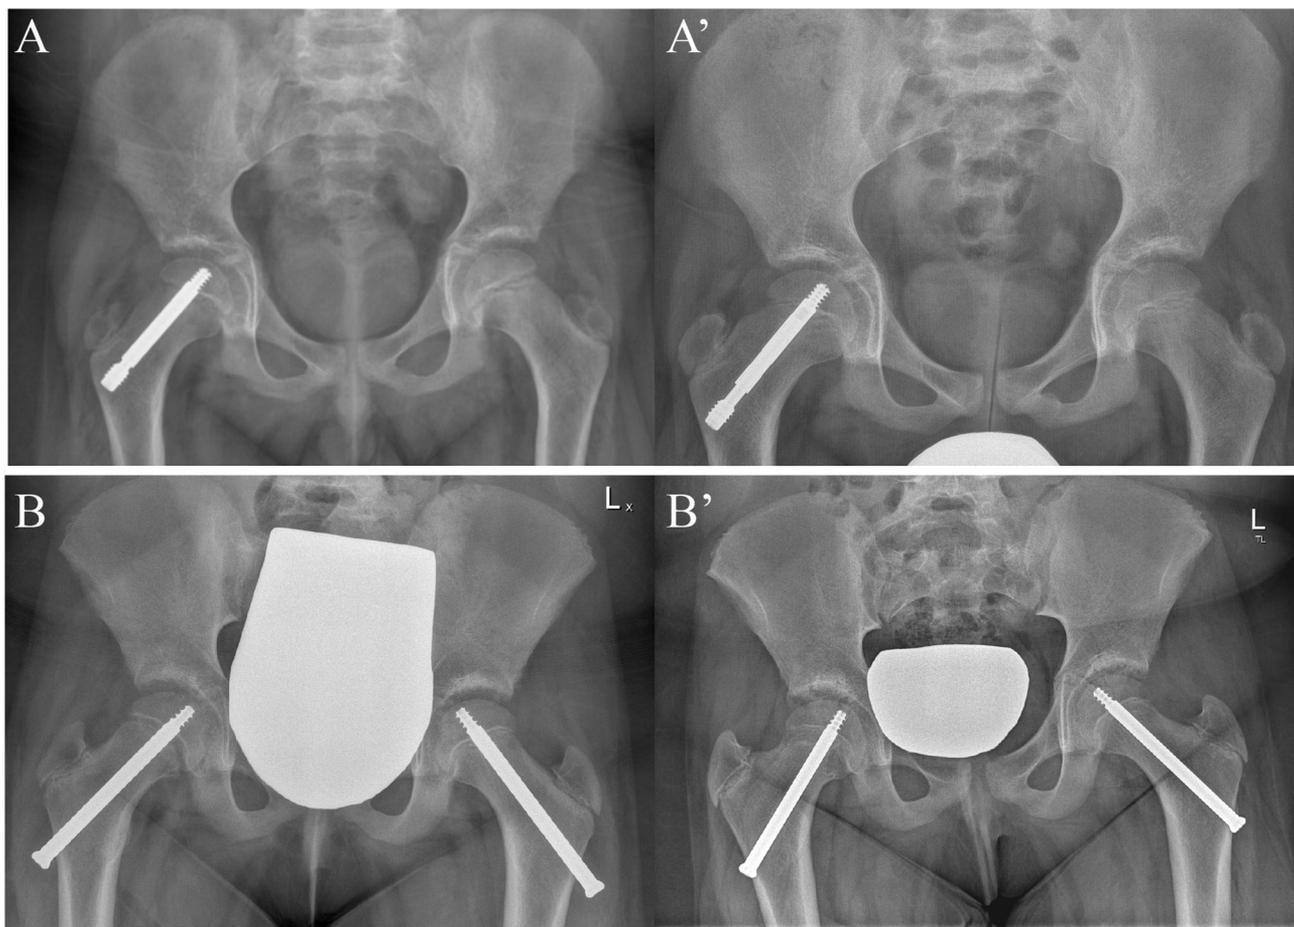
A-A': Initial and last available radiograph of FG Screw (Pega Medical) fixation with 15-month interval. B-B': Initial and last available radiograph of Synthes SCFE Screw (Depuy-Synthes) with 19-month interval, after one screw exchange at 12 months.
